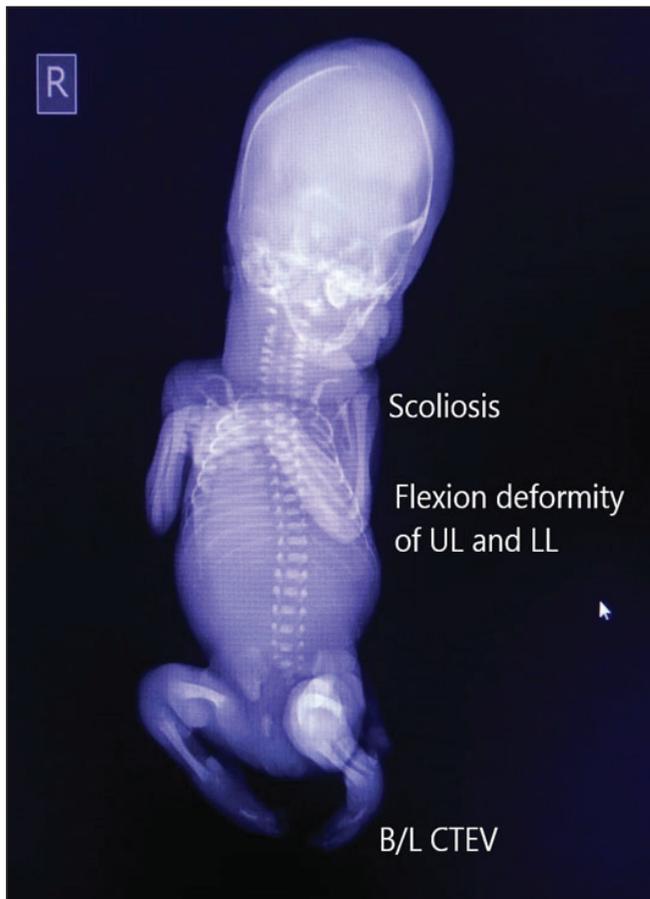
Post delivery radiographs of stillborn (AP and Lat) fetus showing flexion deformity of both UL and LL, micrognathia, skull deformity, bilateral clubfeet and scoliosis.
